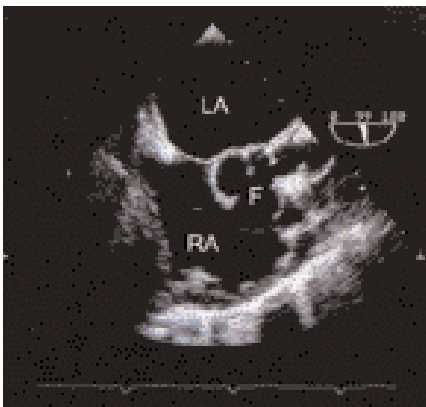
Transoesophageal echocardiogram image in the vertical plane showing the left atrium (LA) and right atrium (RA) with a tortuous left coronary artery fistula (F) draining into the RA.
